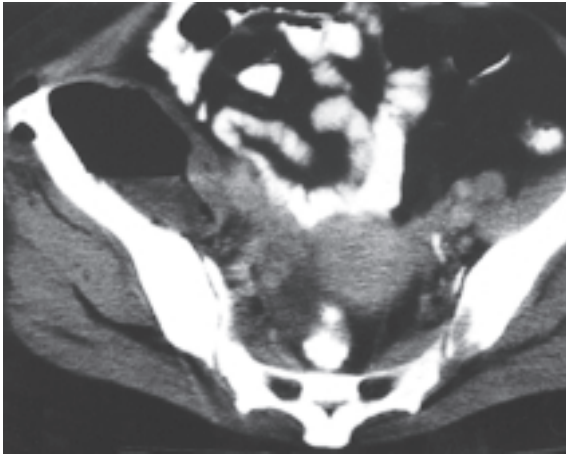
Secondary iliopsoas abscess in a 47-year-old woman with right iliac osteomyelitis. Unenhanced axial CT scan shows a large swelling of the right iliopsoas muscle, with an air-fluid level within it. Organism cultured was *Salmonella enteritidis*.
